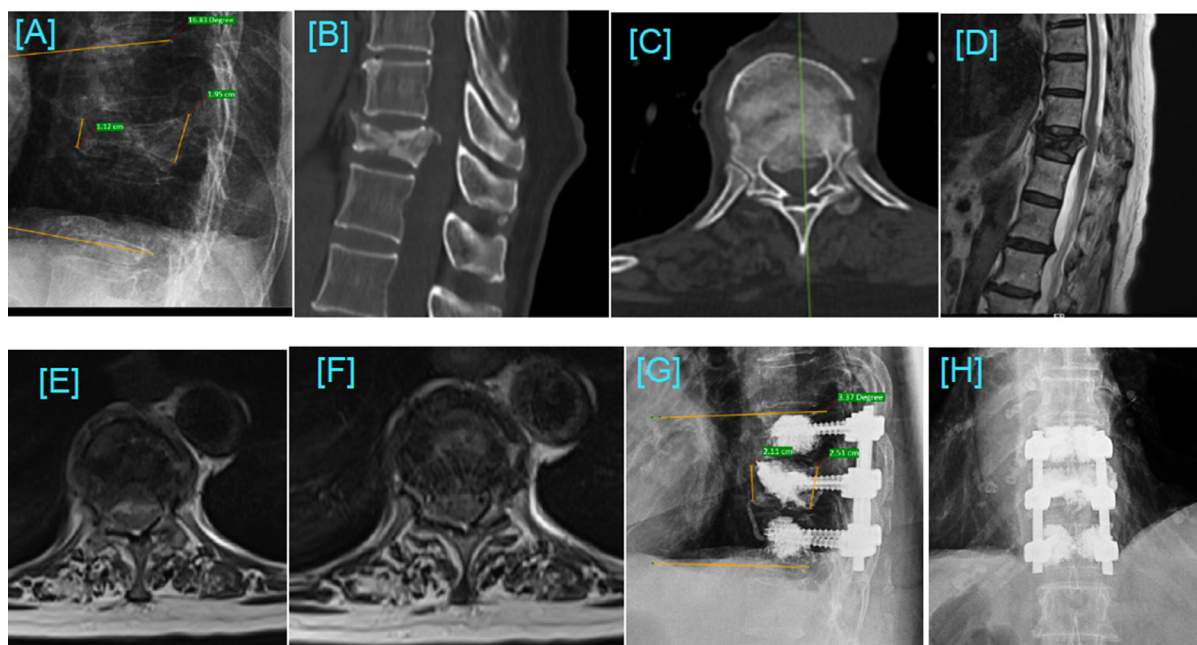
80-year-old Female patient with D11 osteoporotic burst fracture underwent Vertebroplasty with cement augmented pedicle screws short segment fixation. [A,B] The preoperative lateral radiograph, sagittal CT scan showed D11 fracture, the kyphosis angle was 16.81° , anterior vertebral height was 57.43%. [C] Axial CT Scan shows retro-pulse posterior wall fragment. [D,E,F] MRI was suggested of D11 vertebral fresh fracture with canal stenosis. [G,H] Postoperative final follow-up radiographs showed the fractured vertebra was restored with local kyphotic angle was 3.37° degree, and the anterior vertebral height was almost normal (84.06%).
